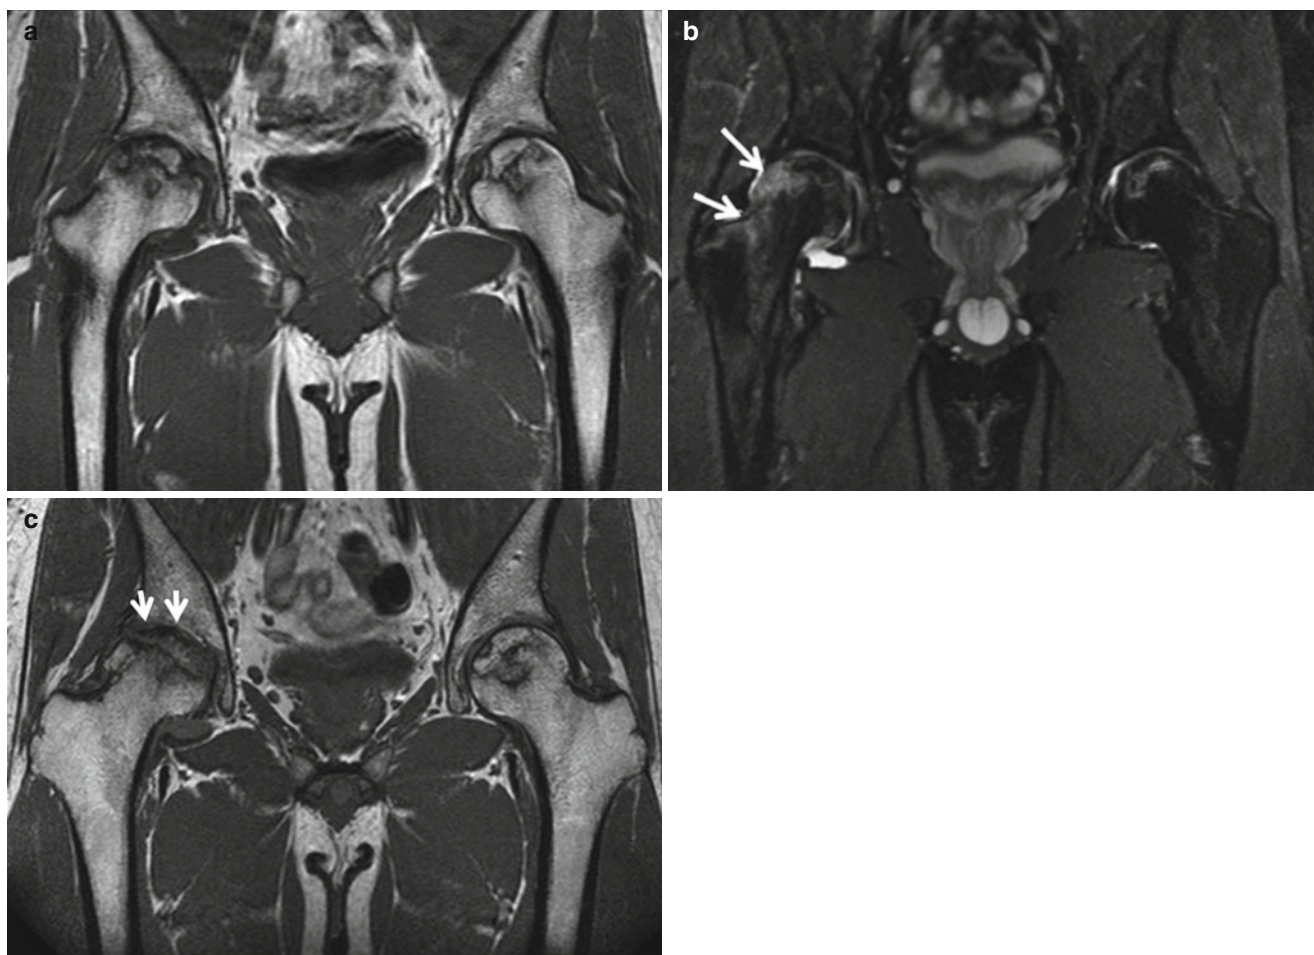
ON of both femoral heads. (a) At both femoral heads, ON with band-like low signals is noted with similar involving areas on T1-weighted coronal MR image. (b) In the right femoral head and intertrochanteric area, bone marrow edema (*arrows*) is noted on T2-weighted fat-suppressed coronal MR image. In contrast, there is no
